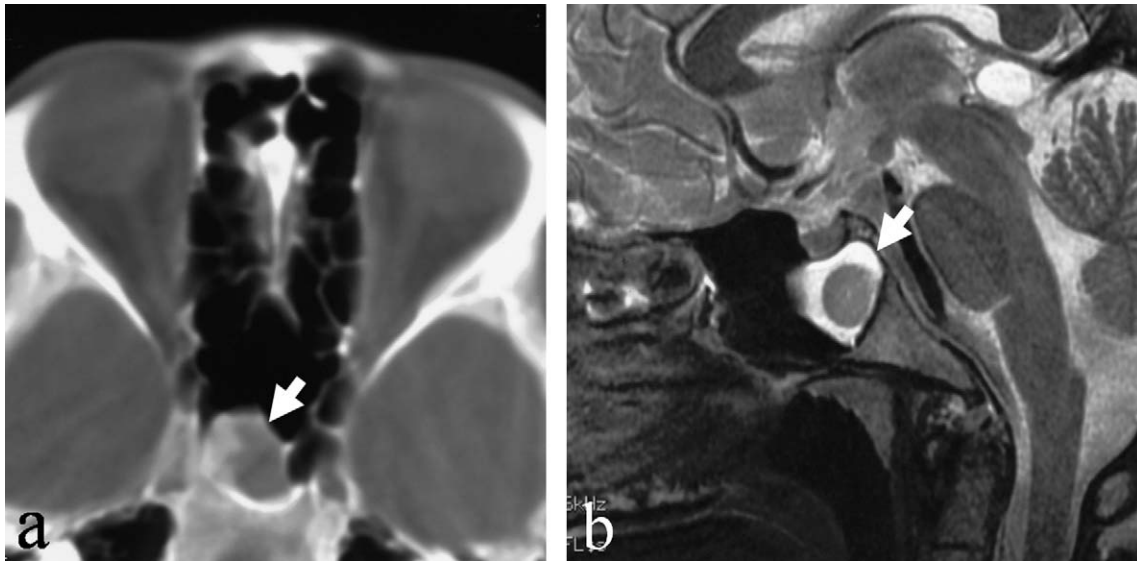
Preoperative CT and MRI (Case 6). (a) Axial CT: a round mass lesion is seen in the right sphenoid sinus, close to the skull base (white arrow). (b) Sagittal MRI: a low-density cystic lesion surrounding a high-density area is seen (white arrow).
